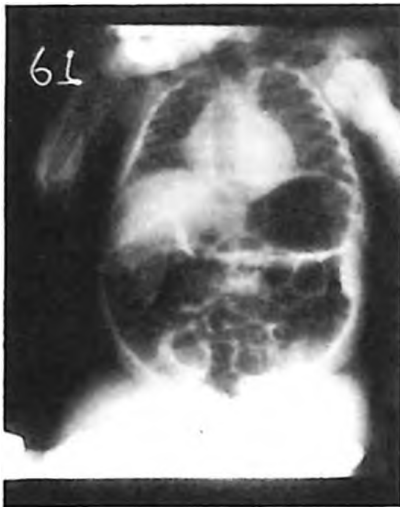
The roentgenogram showing hyperinflation of the lungs and intestines.
